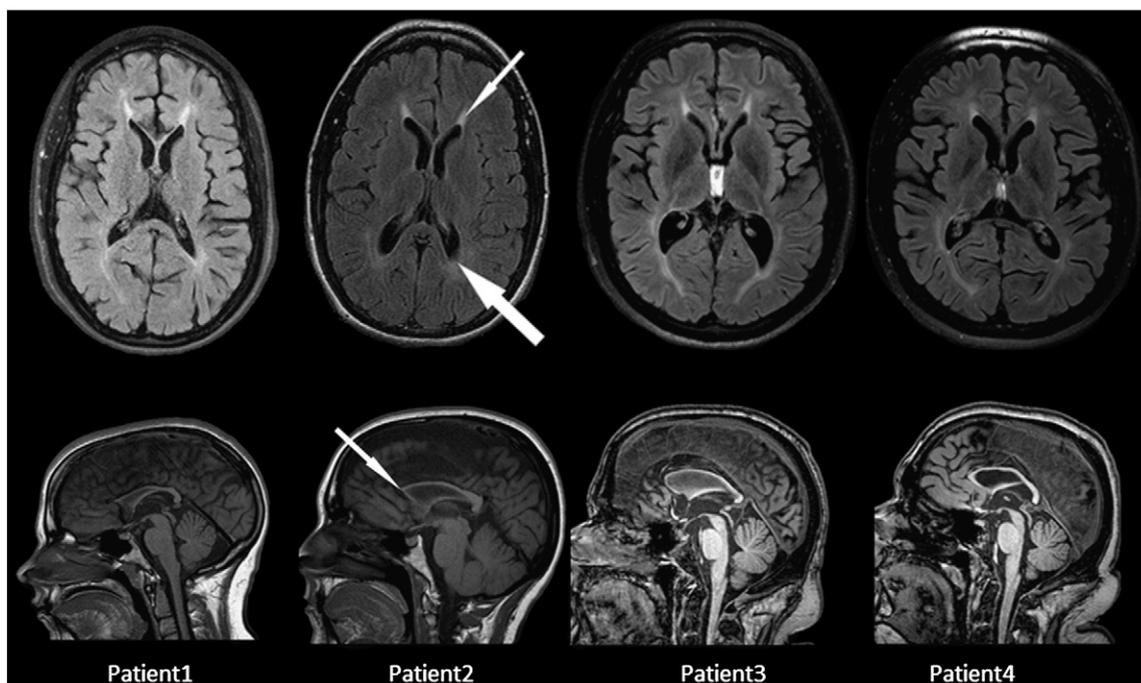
Top portion: magnetic resonance imaging: MR T2-weighted axial scan. All patients showed the “ears of lynx” sign consisting of signal changes of periventricular white matter in the frontal region centered in the area of the forceps minor of the corpus callosum (thin white arrow). Patients also demonstrated white matter atrophy (thick white arrow). Bottom portion: magnetic resonance imaging: MR T2-weighted sagittal scan. All patients had a thin corpus callosum more pronounced in the mid and anterior portions with relative sparing of the splenium. This abnormality results in a “beaked” appearance of the anterior portion of the corpus callosum considered characteristic of SPG11 (thin white arrow).
